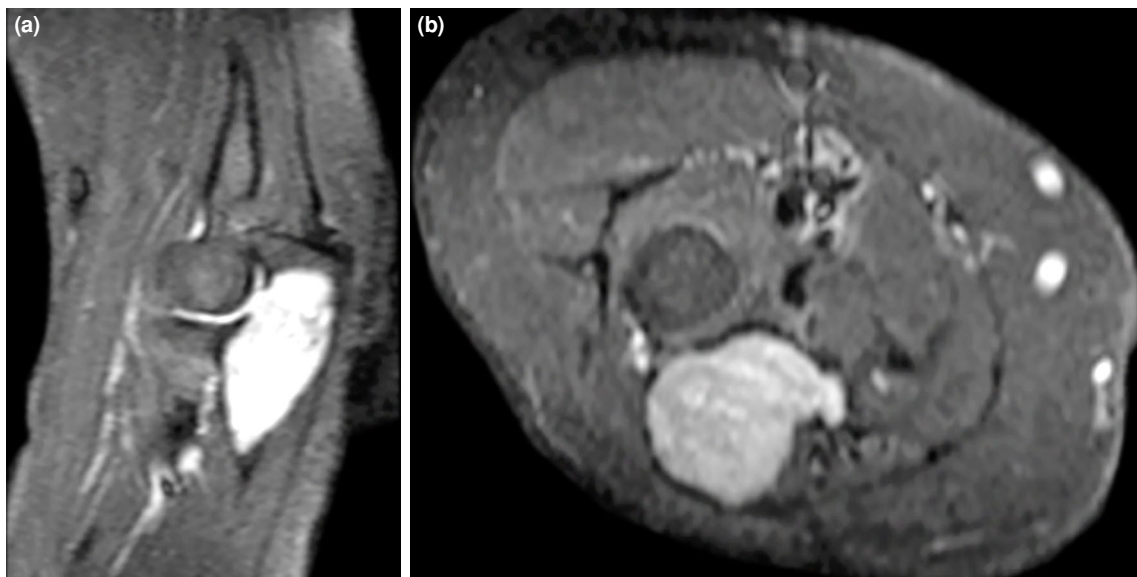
Preoperative magnetic resonance imaging appearance. T2-weighted images. (a) sagittal section (b) axial section.
